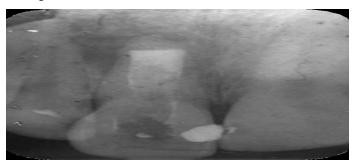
Radiography of MTA apical plug.
